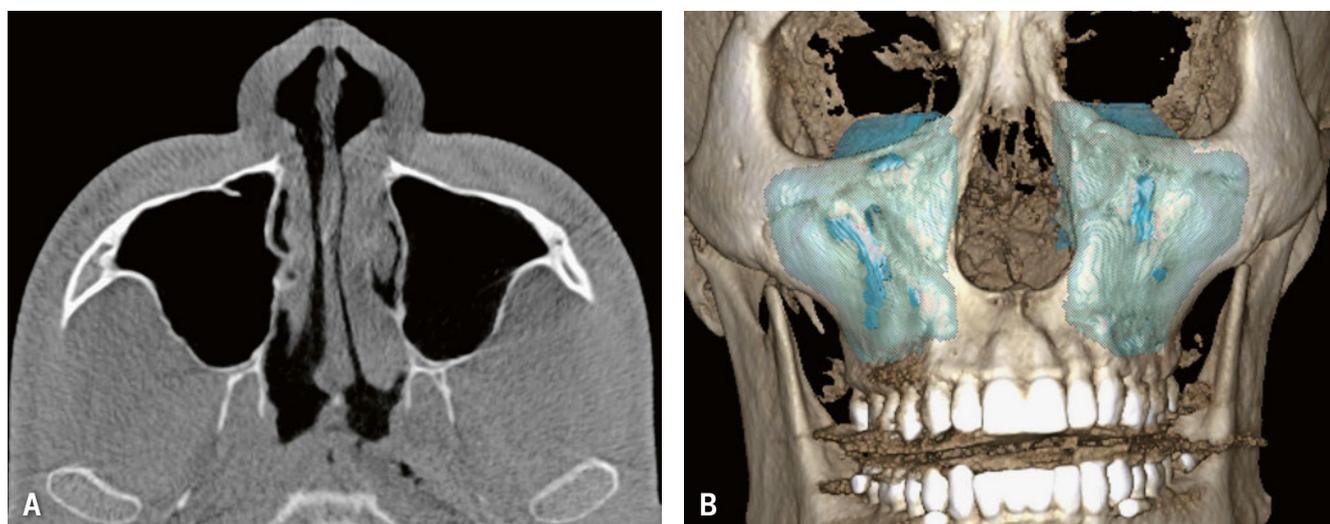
Volumetric measurement of a large (34.0 cm^3 , value averaged from both observers) right maxillary sinus of a 25-year-old male patient imaged using CBCT. (A) Sinus visualization in an axial slice; (B) volume rendering (turquoise) within the skull of the patient.
